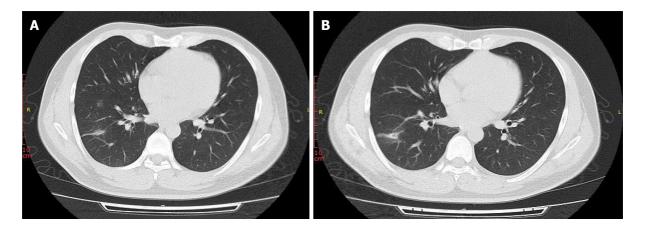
Chest computed tomography scan after 1 mo of antifungal treatment showing resolution of the bilateral lesions. The mass in the right lung was reduced markedly. A: The 25th floor scan; B: The 26th floor scan.
